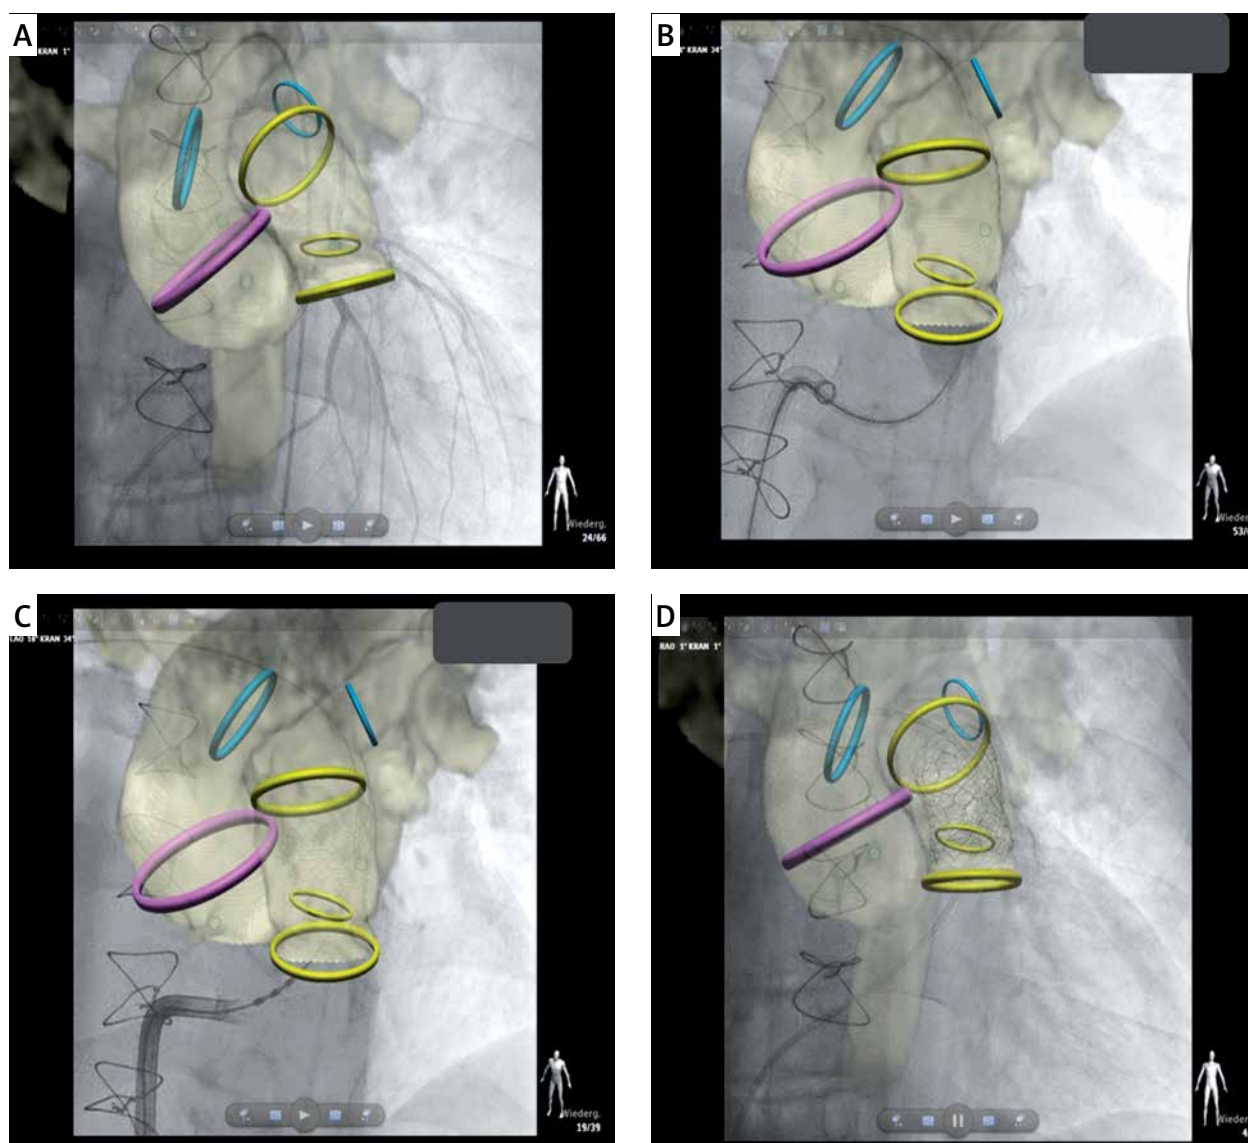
Live three-dimensional guidance of percutaneous pulmonary valve implantation. Magnetic resonance imaging derived three-dimensional roadmap (see Figure 2) was utilized to guide successive steps of the intervention: selective coronary artery angiography (A), pre-stenting with implantation of two covered stents (B), placement of a 26 mm Sapien 3 valve (Edwards) (C) and final angiography (D)
